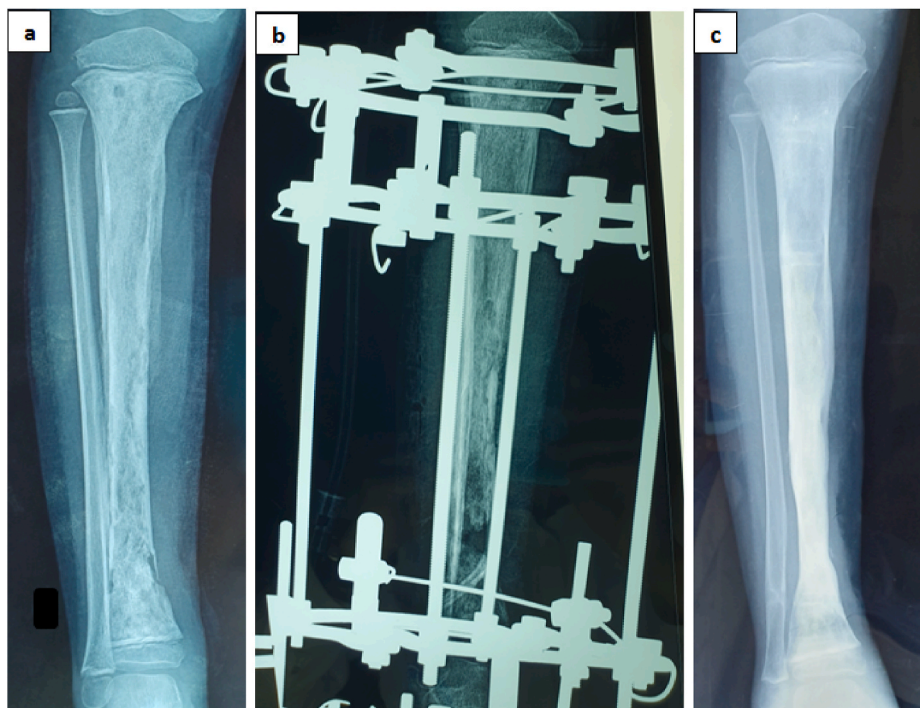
A-P X-ray of right leg: a. pandiaphysitis of the tibia, b. stabilization by an Ilizarov external fixator, c. x-ray at one year.
